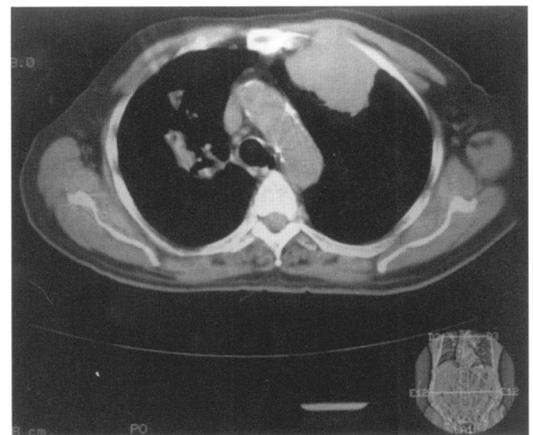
CT scan of the thorax showing a large infiltrating tumour of the left lung and a smaller tumour in the right lung
